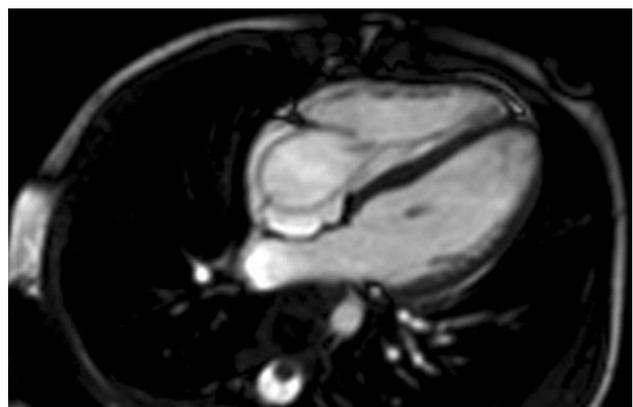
Cardiac MRI showing the dislocated shunt in the four-chamber view
